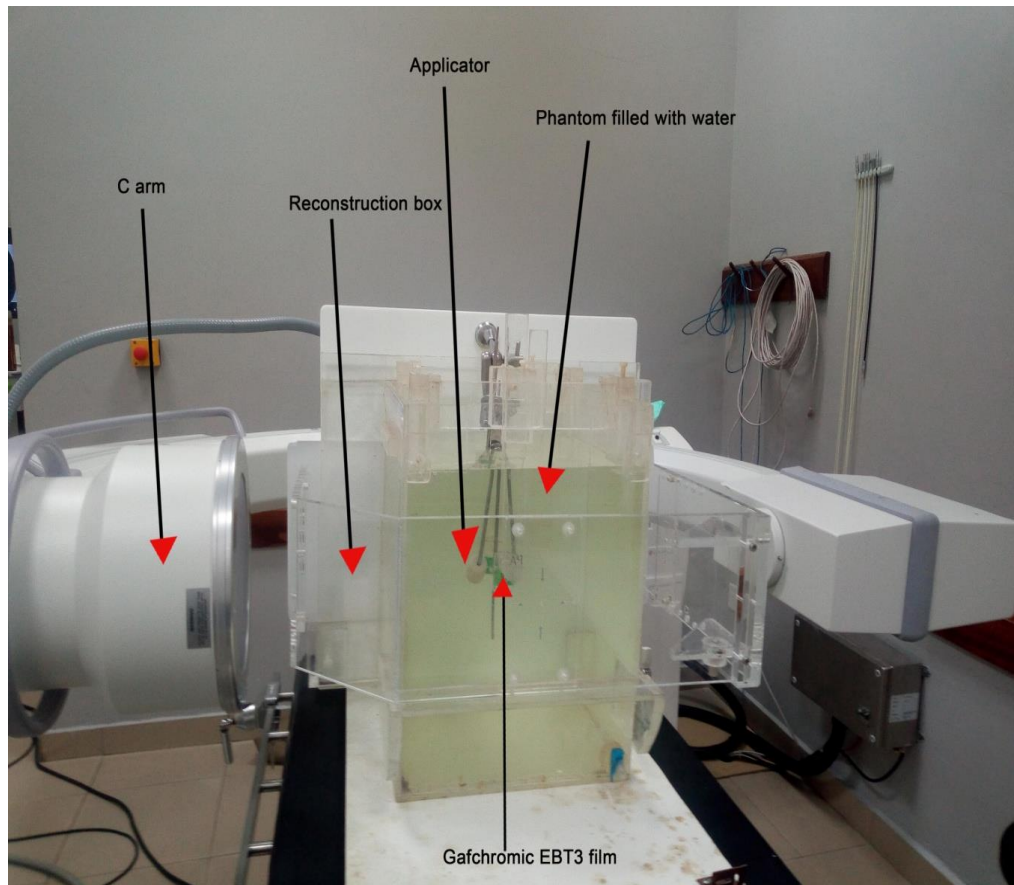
C-arm Fluoroscopic X-Ray Unit in a Lateral Position
